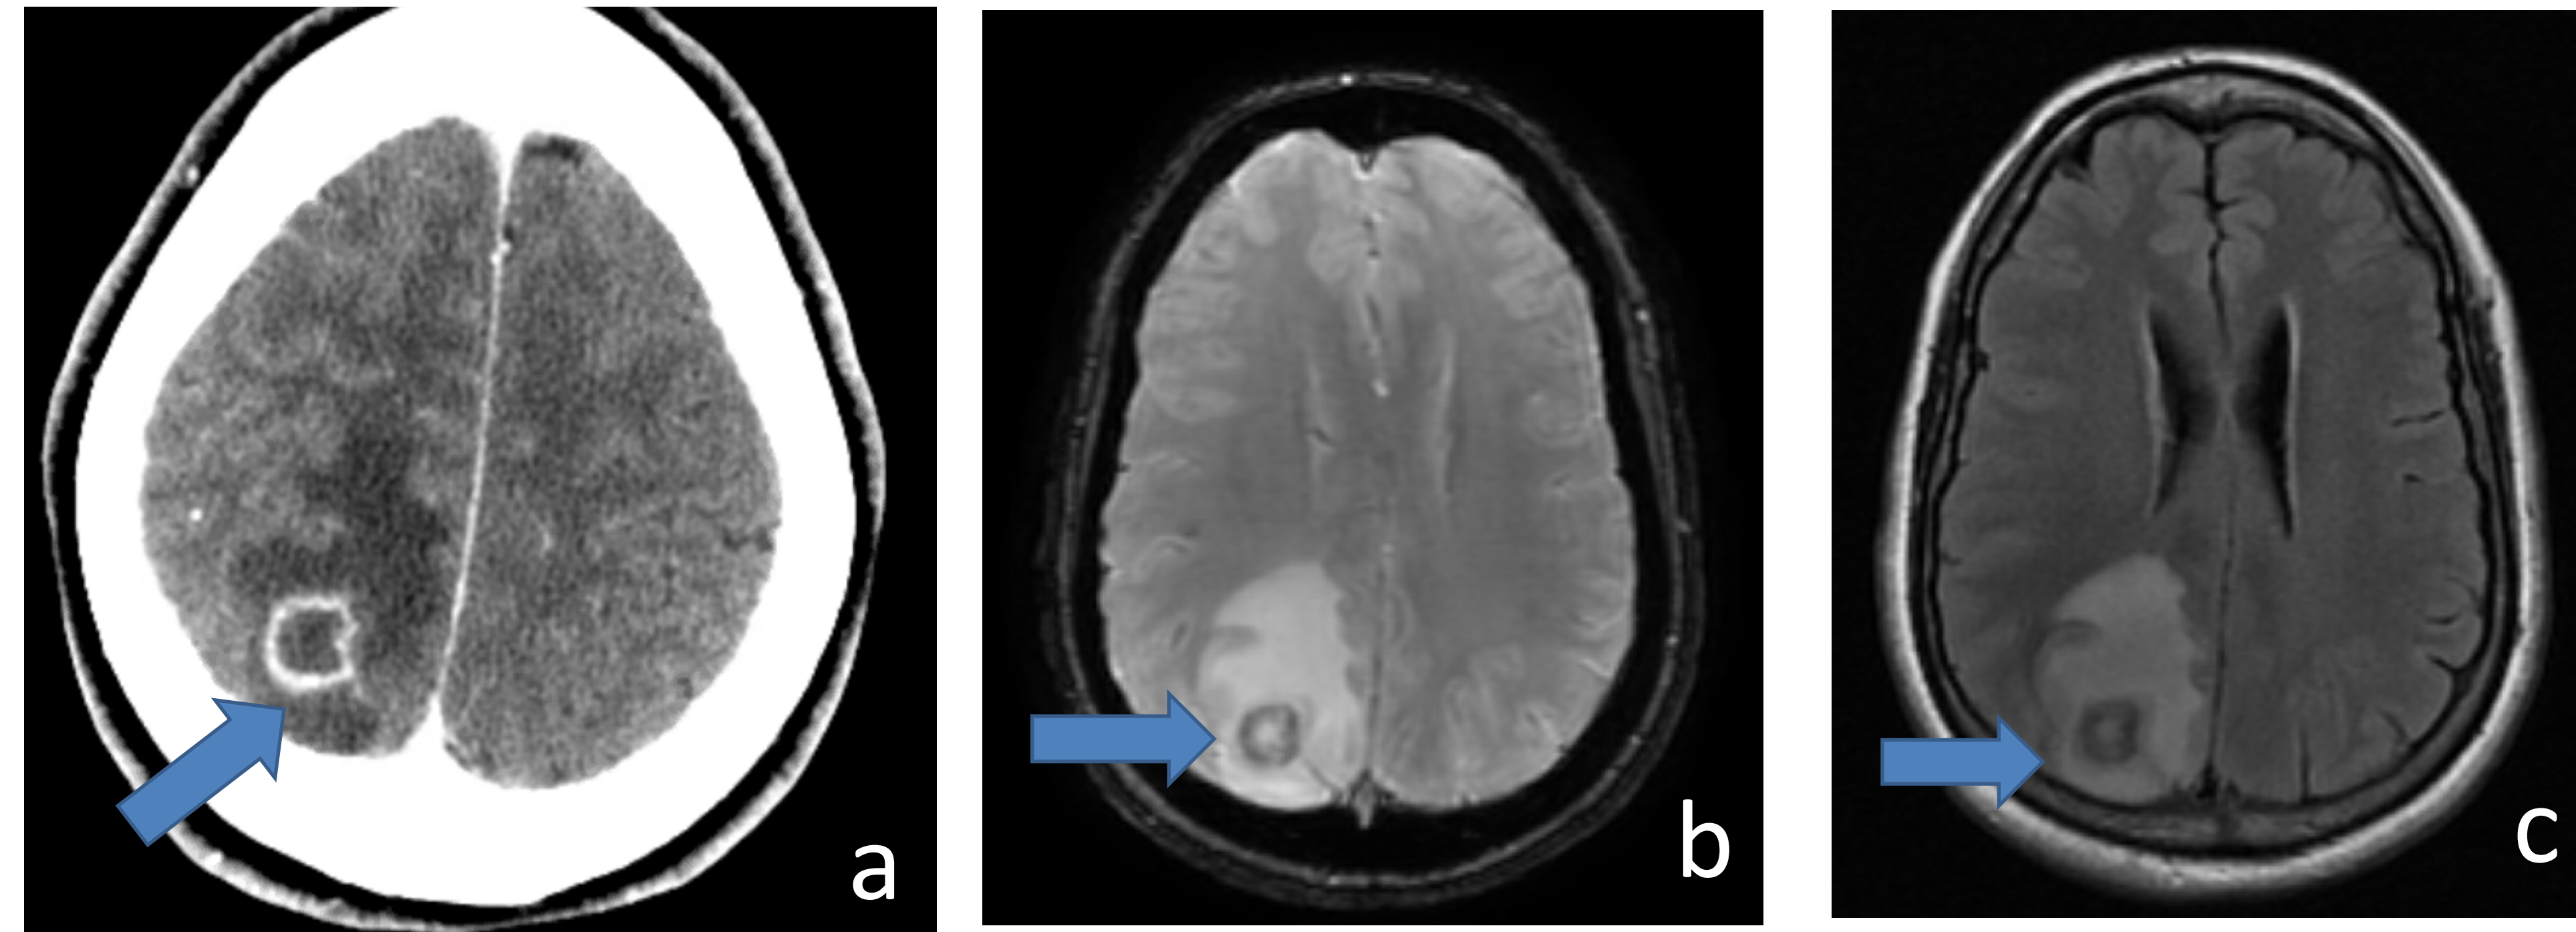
Image a: CT scan brain with <2cm ring enhancing lesion shown with blue arrow
